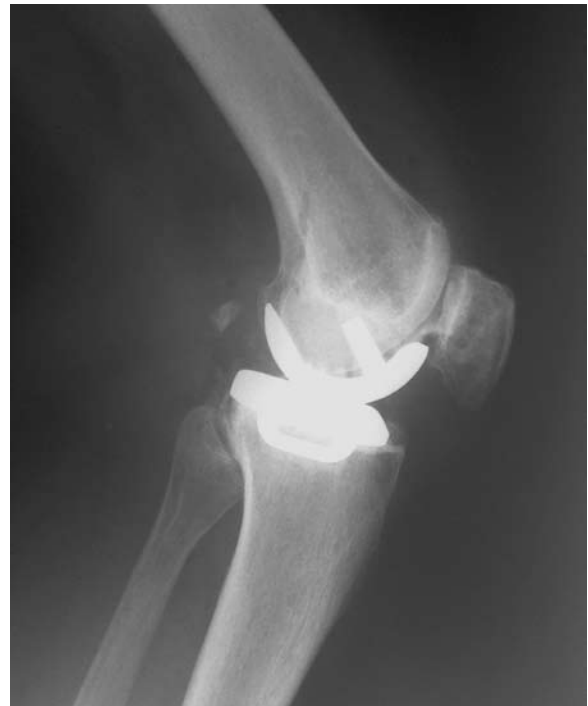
Lateral x-rays of unicompartmental knee arthroplasty following cement removal.
